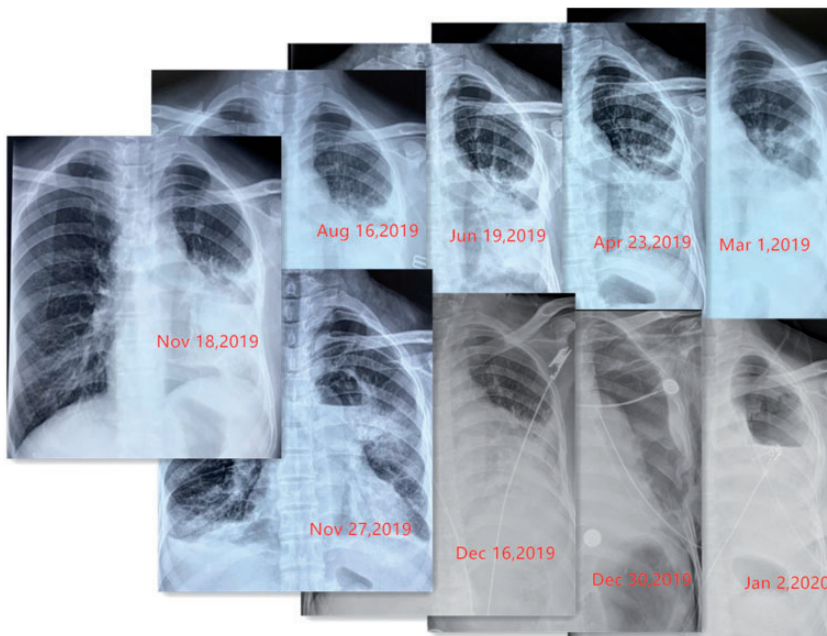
Changes in chest radiographs during treatment from 1 March 2019 to 16 December 2019 and after surgery from 30 December 2019 to 2 January 2020.
